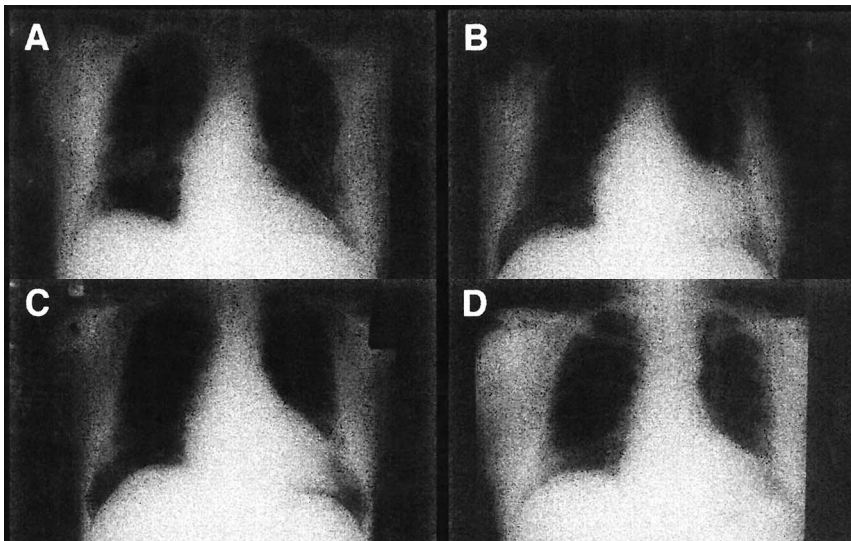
Serial chest radiographs demonstrating reversible cardiomegaly developing with atrial flutter (AF) with normalization following restoration of sinus rhythm (SR). a. February 1996 (SR). b. February 1997 (AF). c. April 1997 (AF). d. August 1997 (SR).
